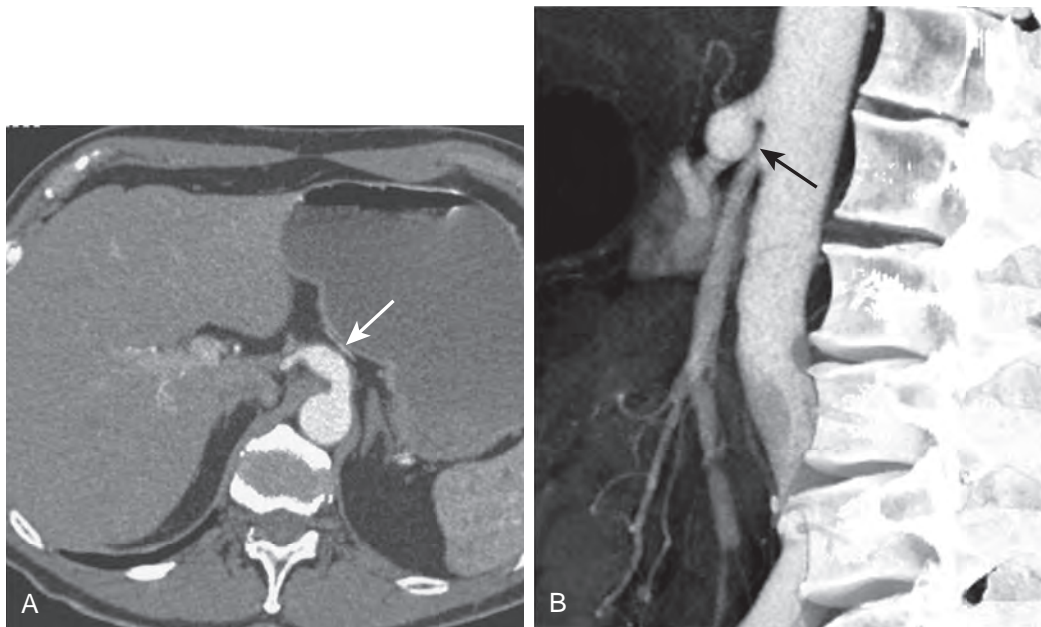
Celiac artery aneurysm. Axial (A) and sagittal (B) contrast-enhanced CT images demonstrate aneurysmal dilation of the celiac axis (arrows).
